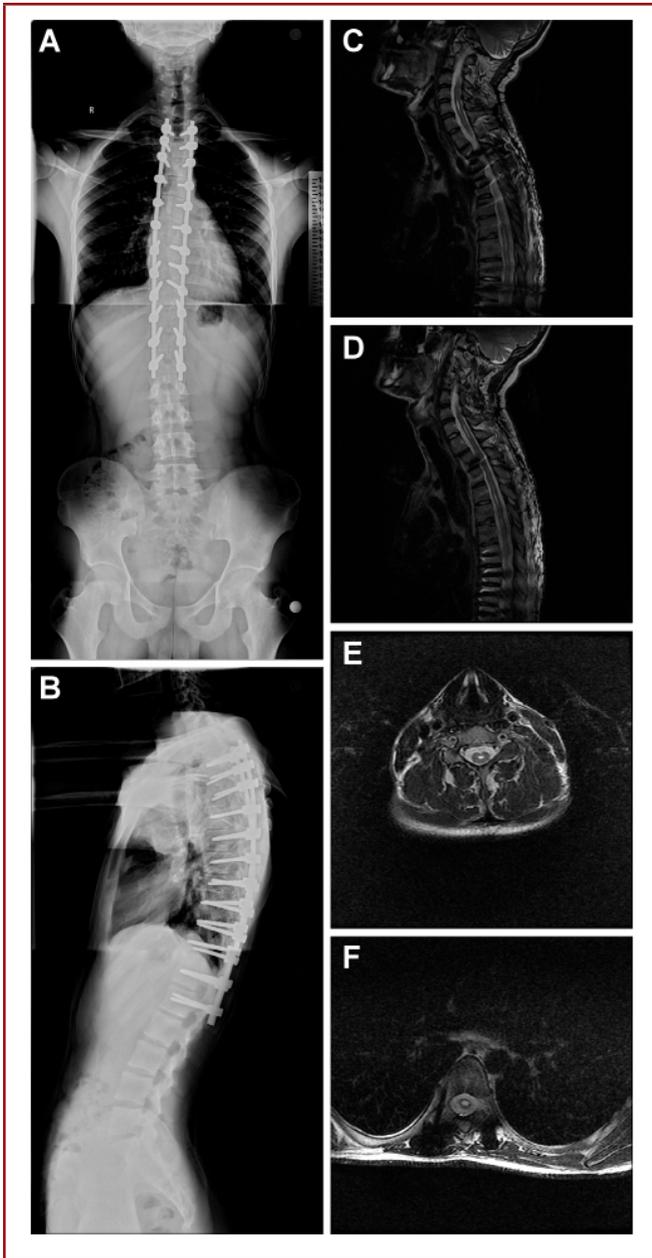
(A-B) Preoperative AP X-ray film indicating double thoracic scoliosis (Cobb angle; 40° and 42°), Cobb angle on lateral graphy is 62°. (C-F) MRI showed extensive syringomyelia in CM-I and cervical and thoracic region (Syrinx level is between C4 and D9, Syrinx Width is 5 mm at C6 level and 7 mm at T6 level).
